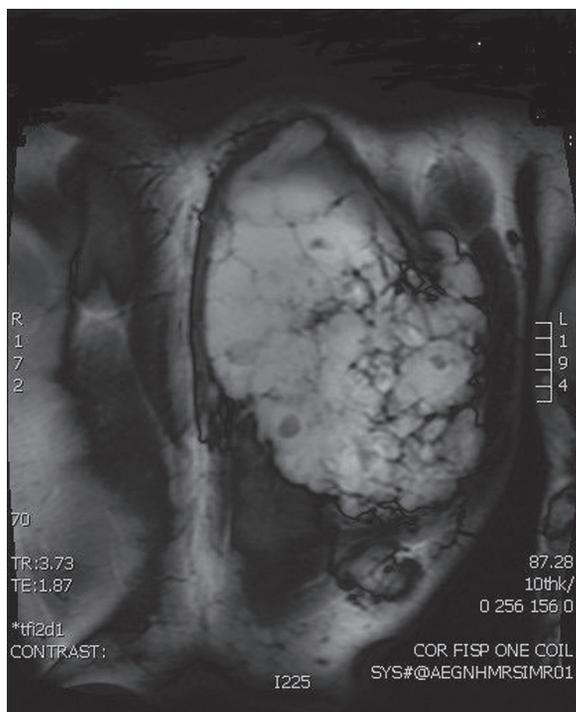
Magnetic resonance imaging of patient showing hemangioma within venous malformation.
